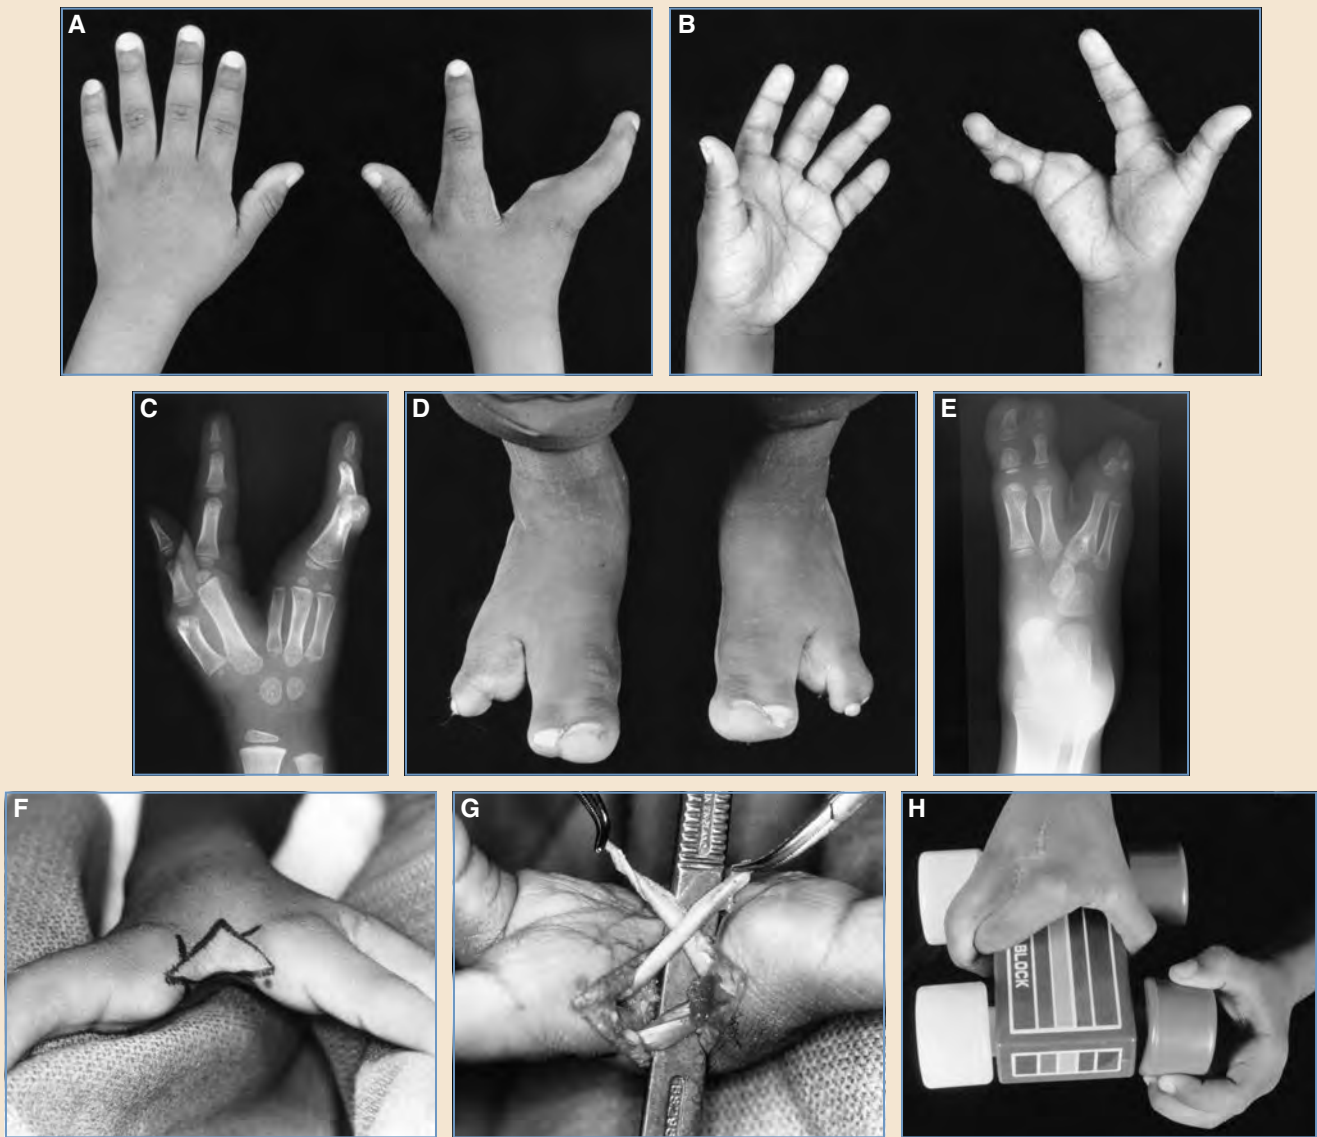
A, Although only one hand is involved, this patient has many features of typical cleft hand. A deep cleft is present in the center of the hand, and adjacent digits are relatively preserved. B, The volar view shows that the central cleft is actually wider than the first web space. The ring and little fingers are fused. C, A radiograph of the hand shows an unsatisfied third metacarpal, fused proximal phalanges of the fourth and fifth digits, a small distal nubbin for the little finger, and a tight first web space. D, Bilateral foot anomalies are seen with suppression of the central ray, soft tissue clefting, and well-proportioned but syndactylyzed border digits. E, Radiography of the right foot shows fusion of the third and fourth metacarpals, absence of the third toe, and a soft tissue cleft. The first surgical step in hand reconstruction in this patient was to ensure that grasp between the thumb and index was sufficient. When the patient was 5 years of age, a four-flap Z-plasty of the first web space was undertaken, along with reconstruction of the ulnar collateral ligament of the metacarpophalangeal joint of the thumb with fascia lata. F, After ensuring in therapy that the patient could transfer gross grasp to the reconstructed first web space, the redundant tissue of the cleft was excised, Z-plasties were performed along the incision lines, and the central cleft was closed in a simple fashion when the patient was 5½ years of age. G, A long segment of fascia lata was harvested and used to reconstruct the deep transverse metacarpal ligament. The fascia was passed in a figure-of-eight fashion around the necks of the metacarpals of the index and ring fingers and secured with a nonabsorbable suture. H, The patient has good hand function after cleft closure, because the function of the first web space was assessed, reconstructed, and rehabilitated before cleft closure was undertaken.
